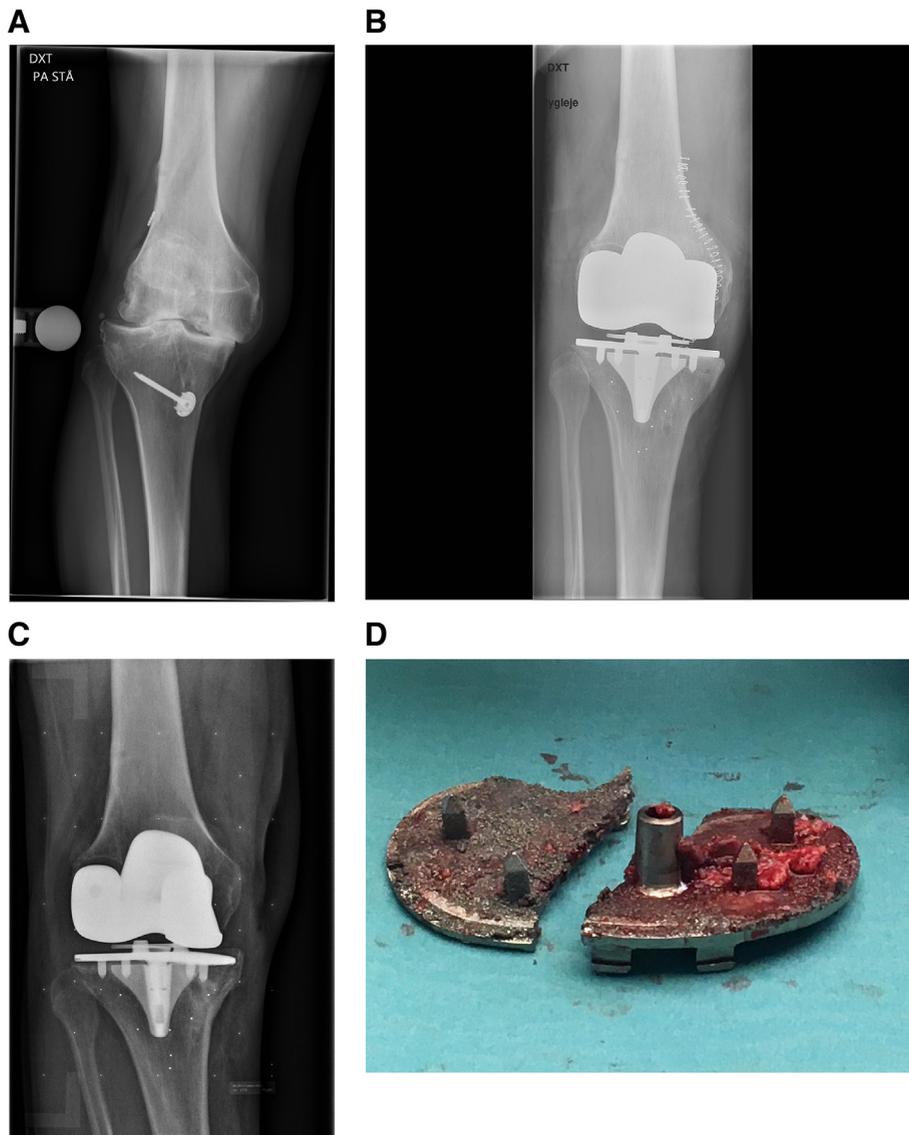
Case 2: Antero-posterior radiograph of the right knee, (A) preoperative, (B) postoperative, (C) 12 months after primary surgery, and (D) picture of retrieved tibia component with fracture of the metallic baseplate.
